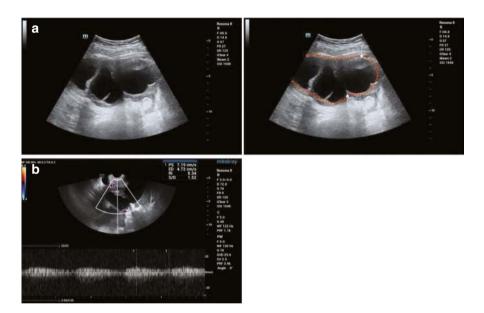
(a) B-mode ultrasound reveals a predominantly cystic tumor with irregular thickening of the tumor wall and thick, uneven septations. The tumor is circled in orange; the upper arrow points to a thick segment of the tumor wall, and the lower arrow points to a thin segment. (b) Spectral Doppler ultrasound shows a low-resistance arterial spectrum
